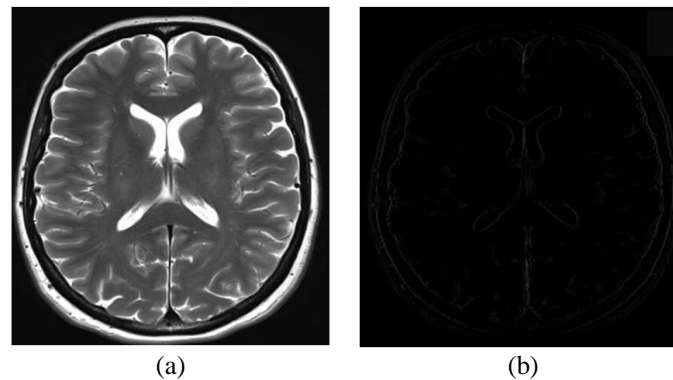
Baseline reference images for normal brain tissue (a) the MRI before any tissue growth and (b) its corresponding IBIGP image
